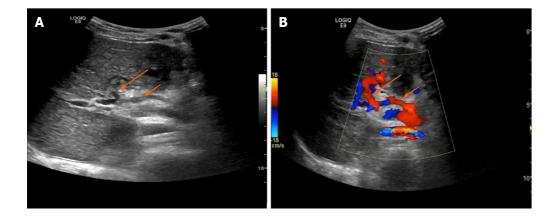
Grayscale and color Doppler ultrasonography of an 8-year-old girl after recanalized umbilical vein as a conduit for Rex shunt. A: Grayscale ultrasonography; B: Color Doppler ultrasonography. The girl was admitted to hospital with intermittent hematemesis and black stool. Bypassing the main portal vein with the umbilical vein was conducted through the splenic vein. The bypass vessel (splenic vein) and anastomoses were clearly displayed 7 d after operation. Long arrow indicates umbilical vein and short arrow indicates splenic vein.
